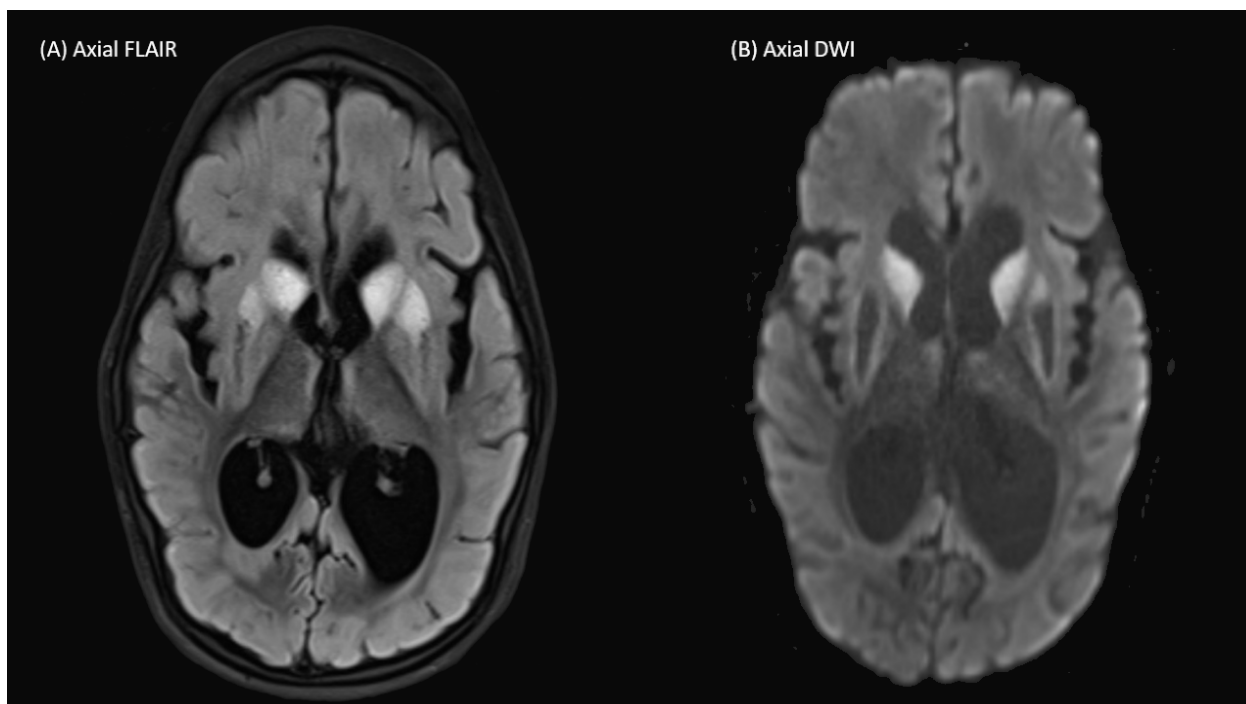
MRI brain obtained two months following cardiac arrest.
